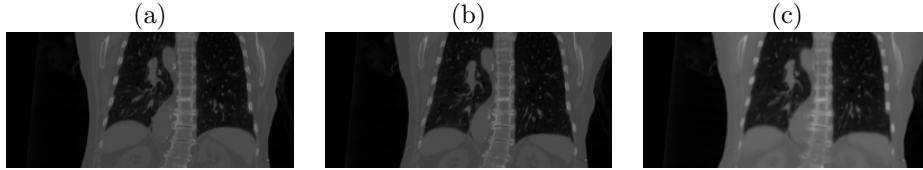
(a) Planning CT at the End-Expiration (EE) phase (b) planning CT at the End-Inspiration (EI) phase and (c) respiratory Fréchet mean CT generated via an LDDMM framework from a lung dataset .
